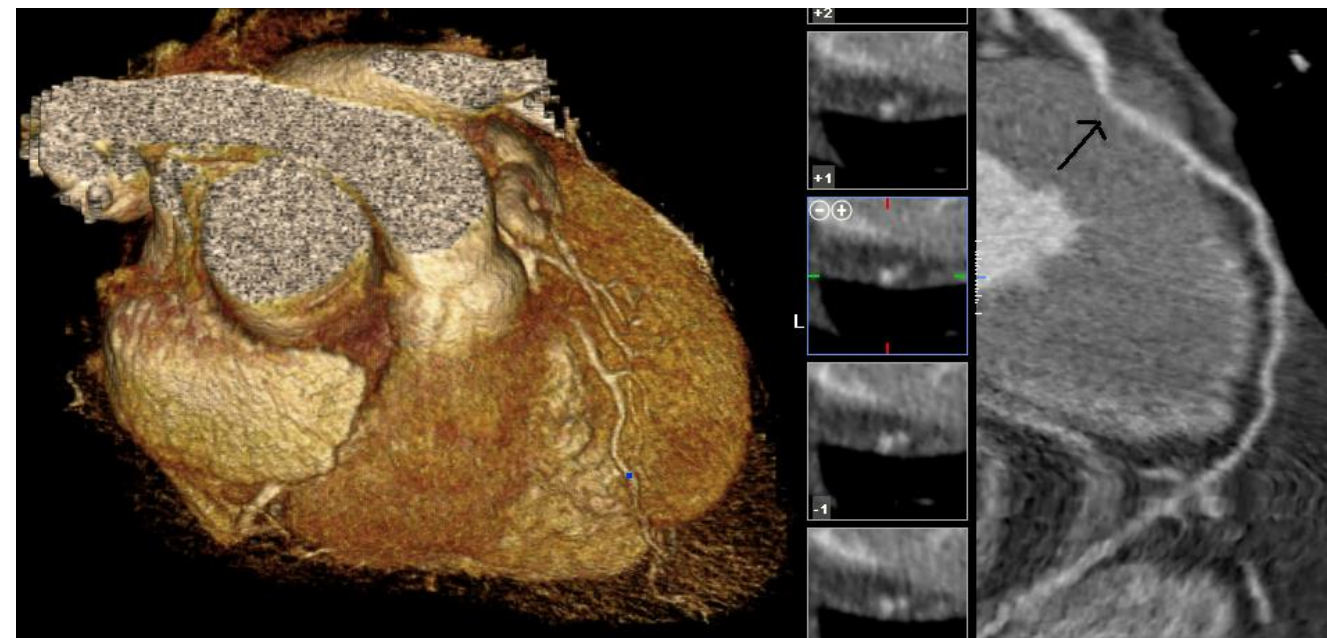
Example of Myocardial bridging of the mid-LAD on curved planar reformatting CT Angiography. Arrow indicates systolic compression of the coronary lumen.⁴
